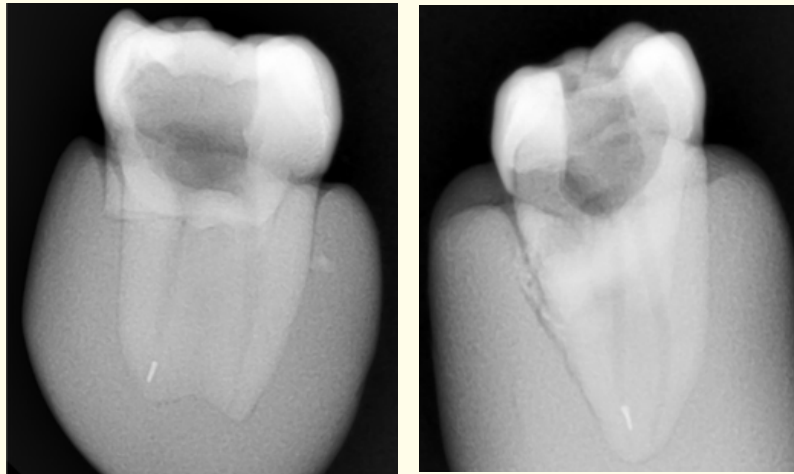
Radiograph of fractured instruments on first mandibular molars mesial canals apical third. Reciproc – Left, WaveOne – right.
